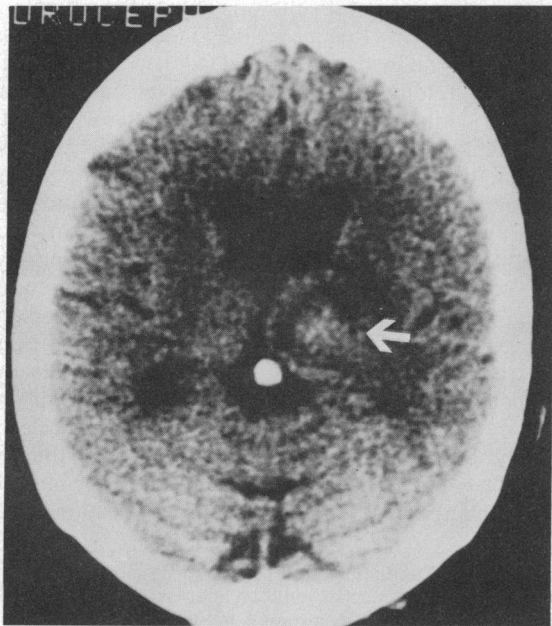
CT scan from patient VM at the time of acute-phase testing 7 weeks after his stroke. There is a resolving large hematoma (arrow) centered in the left pulvinar.
